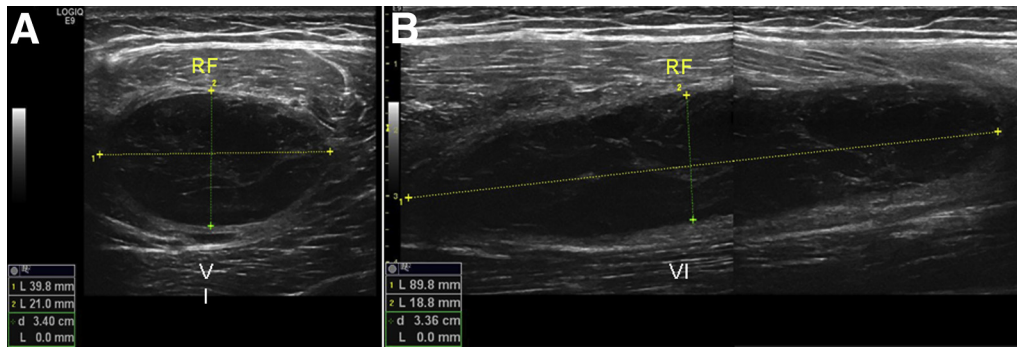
Preoperative ultrasound evaluation of the hematoma. The patient is placed in supine position and the ultrasound probe is placed on the anterolateral aspect of the left thigh. (A) The short-axis view on sonogram shows the hematoma between the rectus femoris (RF) and vastus intermedius (VI) with a diameter of 39.0 mm. (B) The long-axis view shows the hematoma with a diameter of 89.8 mm.
